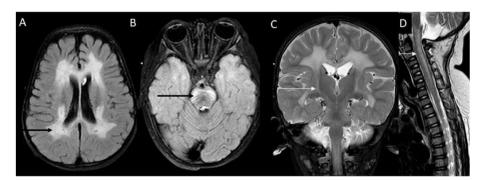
Hypomyelination with brain stem and spinal cord involvement and leg spasticity (HBSL)* Axial FLAIR images show diffuse confluent periventricular and deep white matter hyperintensity (black arrow in A) and symmetric hyperintensities of the pontine corticospinal tracts (black arrow in B). T2 coronal images also show hyperintensities of the corticospinal tracts in the region of PLIC (white arrow in C) as well as along the spinal cord(white arrow in T2 sagittal-D).
